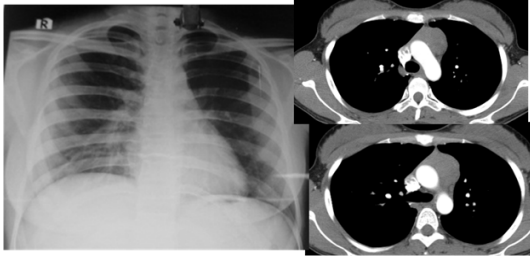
Patient 3: 22F- Type B2- Thymoma –Lesion is invading the pericardium on CT and biopsy also revealed B2 Type of thymoma which is more aggressive
